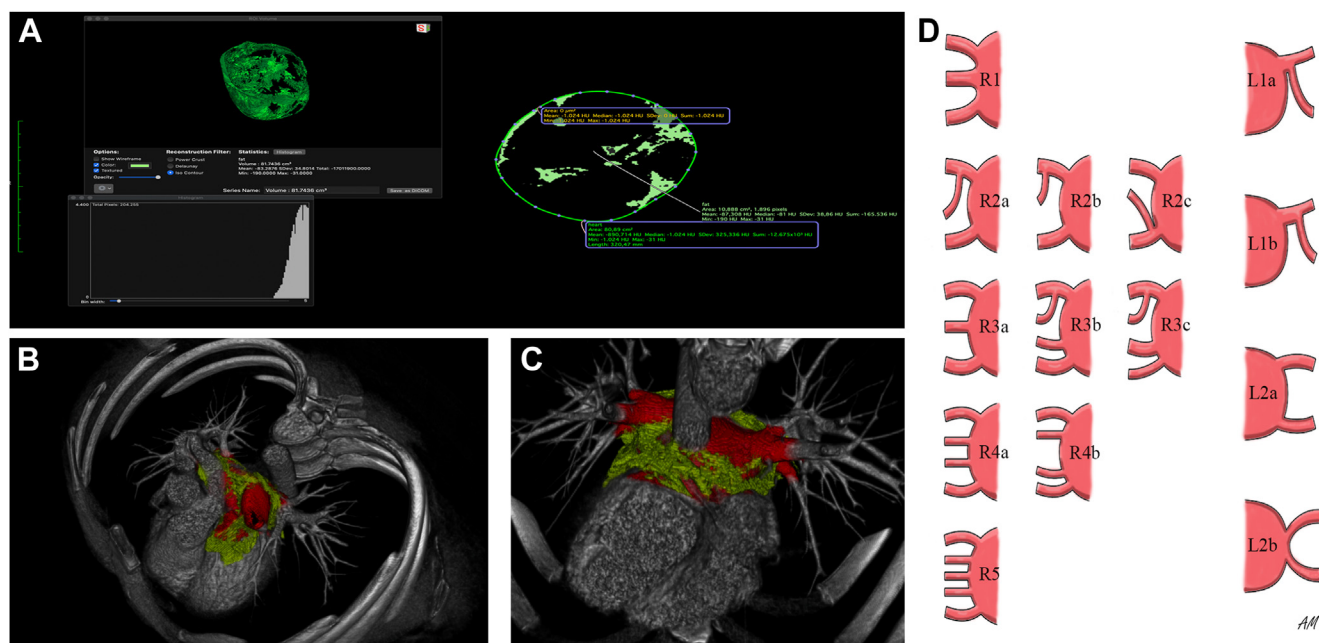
Computed tomography evaluation of epicardial adipose tissue and Marom and colleagues⁹ pulmonary veins classification. A: After encountering the pericardial sac and applying the density requested (−190 to −30 Hounsfield units) epicardial adipose tissue is highlighted (left), volume calculated automatically (right), and 3-dimensional reconstruction allowed after segmentation of the left atrium and pulmonary veins (B: cranial left oblique view; C: inferior view). D: Marom and colleagues' pulmonary veins classification.
